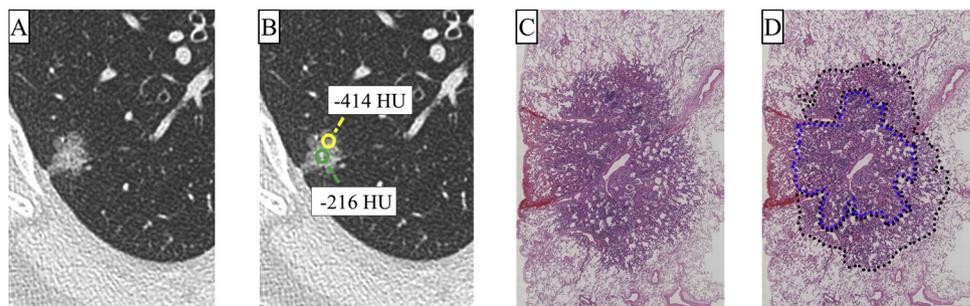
A pure GGO lesion associated with a relapse of multiple lung metastases 3 years after lobectomy. (A and B) Axial CT image shows the pure GGO lesion. The density of GGO was heterogeneous (A). The central area of the lesion was denser than the peripheral area (B). (C and D) This pure GGO lesion revealed lepidic predominant adenocarcinoma (including lepidic and papillary components) (C). The central area of the lesion shows a papillary component (marked by blue dots), and a lepidic component (marked by black dots) is seen around the papillary component (D).
